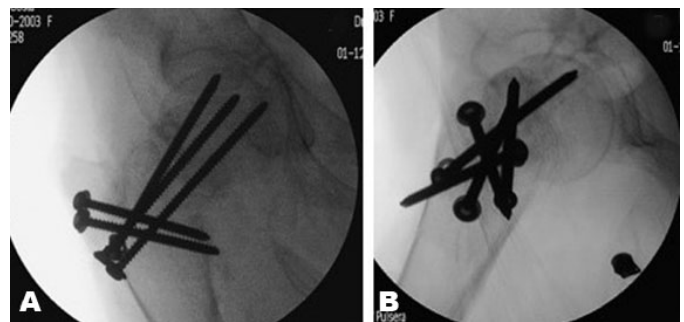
Final intra-operative X-rays showing the reduction achieved in the anteroposterior (A) and lateral (B) views.
